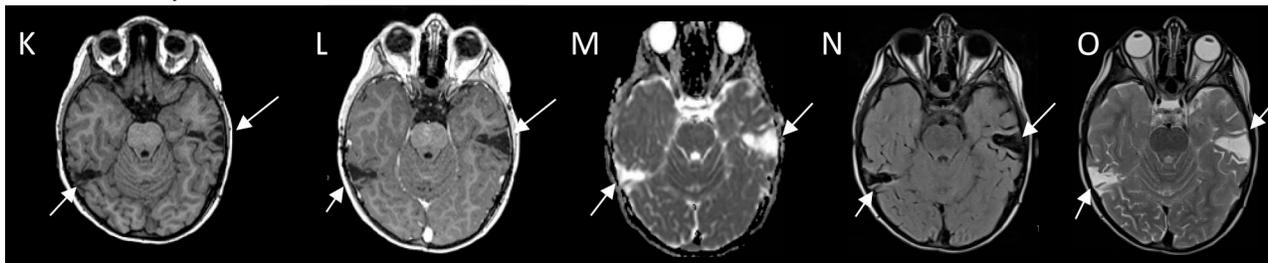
Parasitic infection in a patient with complete *gp91^{phox}* deficiency. Left to right: Brain MRI sequences of axial slices in unenhanced T1, T1 with contrast, diffusion ADC (apparent diffusion coefficient), FLAIR, and T2-weighted images. (A–E) At the level of the brainstem, the presence of two amebiasis
